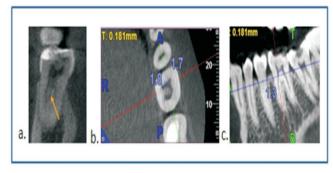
CBCT images – a) Confirmation of MMC b) Measurement of inter-orifice distance between MB-MM and MM-ML, c)Measuring of the distance from the pulpal floor to MMC orifice
